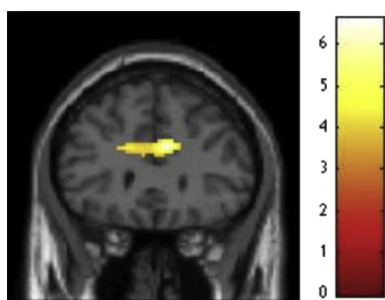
Enclosed spaces activated the anterior midcingulate cortex (aMCC) region of the cingulate gyrus (BA 24) in approach-avoidance decisions. *Notes.* SPM rendered into standard stereotactic space and superimposed on to coronal MRI in standard space. Bar represents magnitude of *T*-score.
